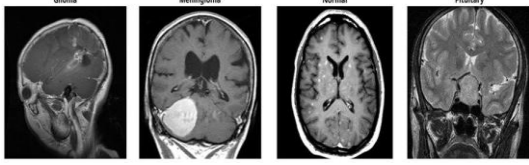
Sample MRI images from the dataset, showing (from left to right) a glioma tumor, a meningioma tumor, a normal brain, and a pituitary tumor.
